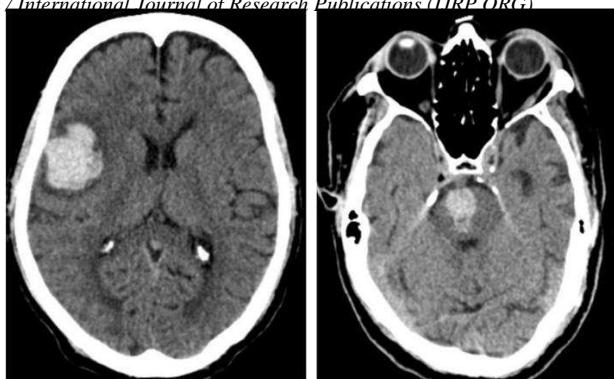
CT scan of the head without contrast, axial view, a. Hyperattenuating/hyperdense lesion in the right frontotemporal lobe with surrounding perifocal edema, b. hyperattenuation in the pons suggests an acute hemorrhagic stroke.
